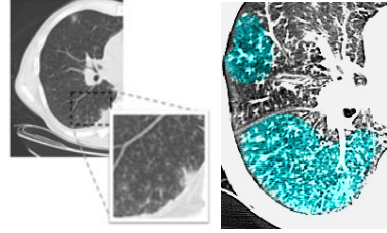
(Left) CT image with a significant amount TIB patterns. (Right) Labelled TIB patterns (blue) in zoomed window on the right lung.
